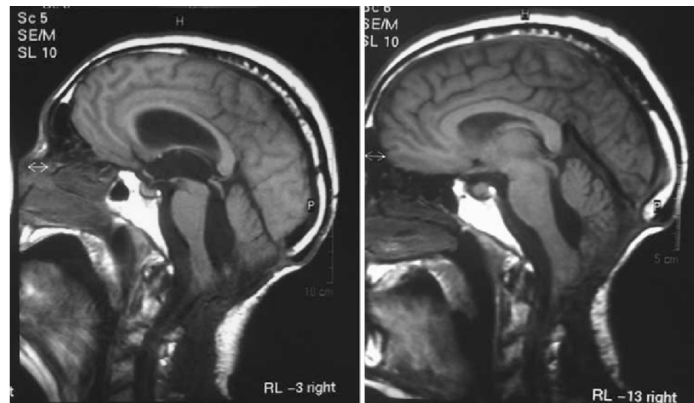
MR image of the brain. Left: communicating hydrocephalus showing an enlarged lateral ventricle and fourth ventricle. Right: decompression of the ventricular system after ventriculoperitoneal shunting [18]
